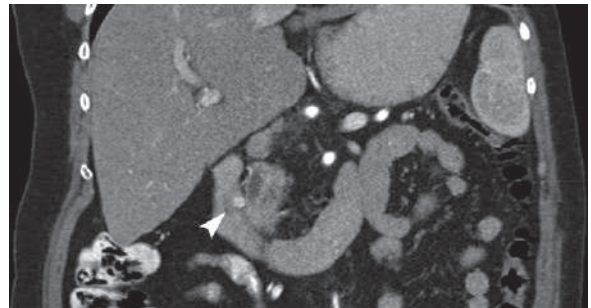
Coronal postcontrast CT image of a patient with Zollinger-Ellison syndrome (ZES) shows highly enhanced nodule located between the second part of the duodenum and the pancreatic head within the boundaries of the gastrinoma triangle representing gastrinoma (*arrowhead*)
